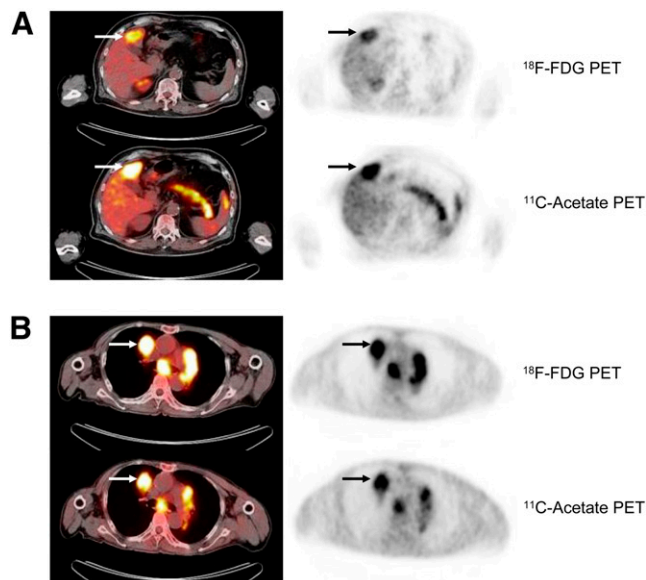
Detection of HCC with ^{18}F -FDG PET/CT and ^{11}C -acetate PET/CT on transaxial sections of liver and chest. Panels on left show PET/CT, and panels on right show PET. (A) Primary HCC of liver was markedly positive for uptake with both tracers (arrows). (B) Metastatic HCC of upper lobe of right lung was markedly positive for uptake with both tracers (arrows).
